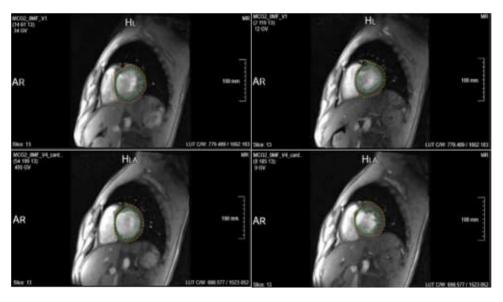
Comparison of enddiastolic and endsystolic midsystolic anatomy left ventricle in short axis (MRI). Upper row presents baseline measurement, lower row measurements of follow-up two months after study. Improved lateral and inferior systolic functions led to an increased LVEF from 36% in baseline to 48% in follow up (MRI).
